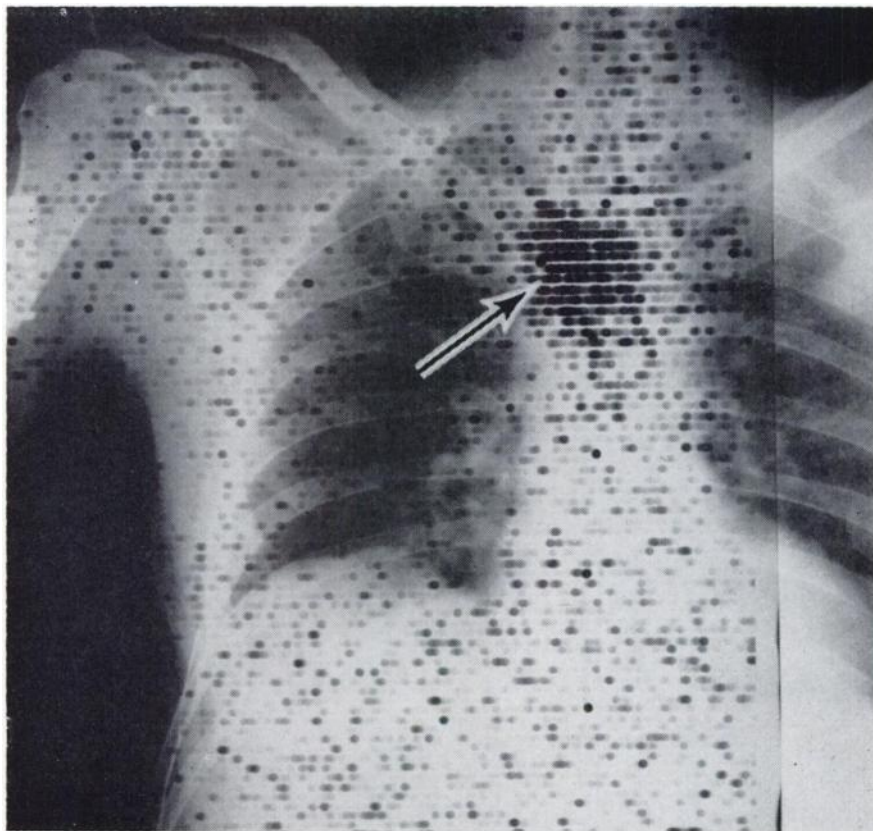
This 54 year old male underwent colon resection three months previously for carcinoma, and recently developed pain in sternum. Roentgenograms were negative. Sr-⁸⁵ scan shows marked accumulation of isotope in body of sternum (arrow). Bone biopsy revealed metastatic adenocarcinoma. Note slightly increased strontium deposition in right shoulder joint (normal).
